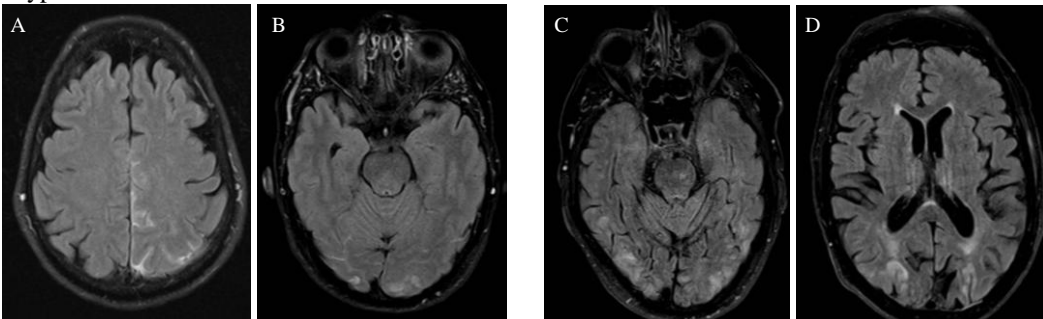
Brain MRI of patient 1 (A, B) and patient 2 (C, D) showing a picture typical and suggestive of PRES.
